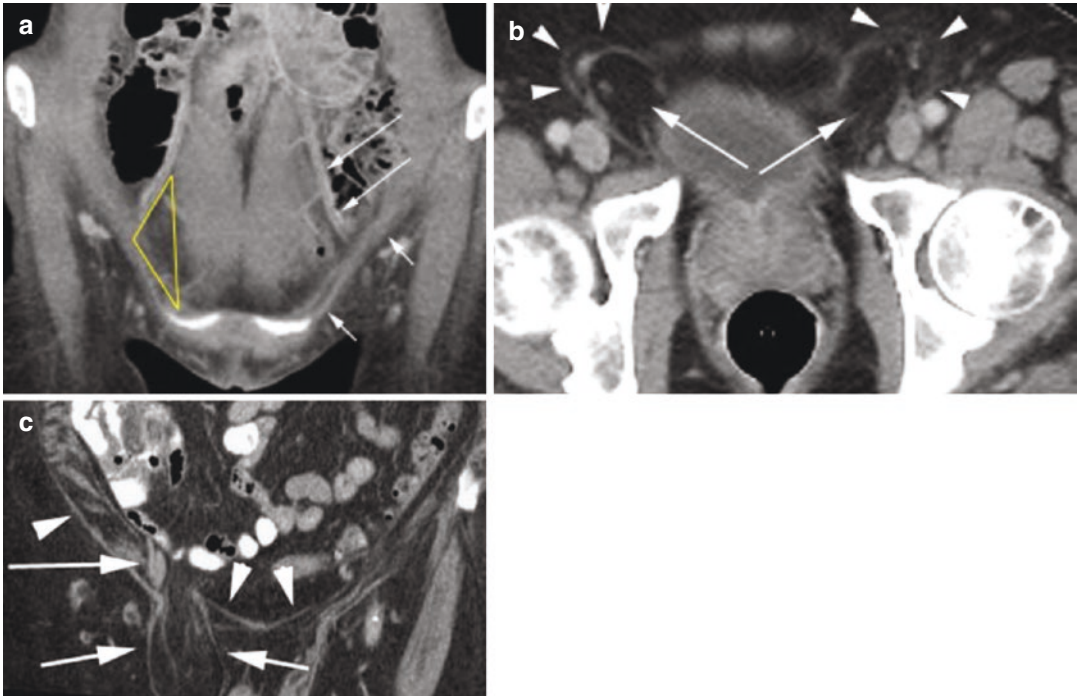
(a) CT coronal reformat demonstrates the inguinal ligament (short arrows) and deep inferior epigastric vessels (long arrows). The Hesselbach's triangle is outlined in yellow on the right which superolaterally is margined by the epigastric vessels, medially by the rectus abdominus, and inferiorly by the inguinal ligament. (b) Axial CT demonstrates a lateral crescent sign due to a fat containing direct inguinal hernias (arrows) displacing the contents of the inguinal canal laterally and the fat
